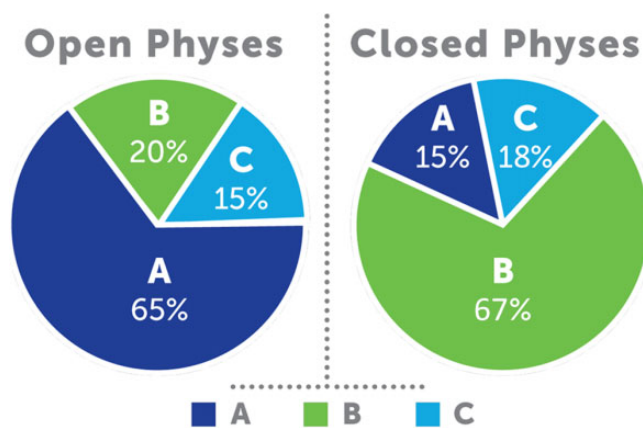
Radiographic incorporation of graft at 1-year follow-up by skeletal maturity. Grade A, 100% incorporation; grade B, $\geq 50\%$ incorporation; grade C, $< 50\%$ incorporation.
